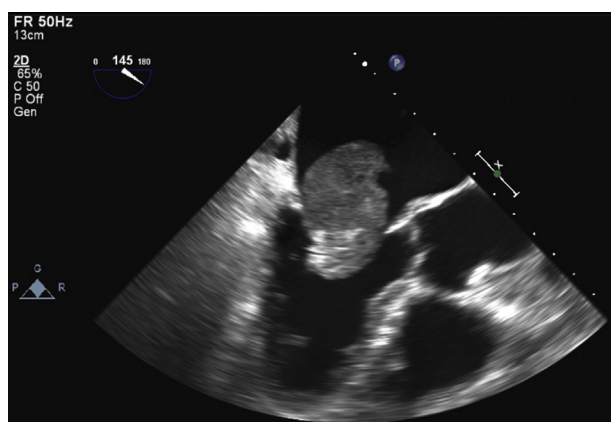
Transesophageal long-axis view showing one of the left atrial masses entering the mitral orifice in ventricular diastole. The mitral valve leaflets open normally ([Supplemental Video 3](#)), with no evidence of mitral stenosis.
